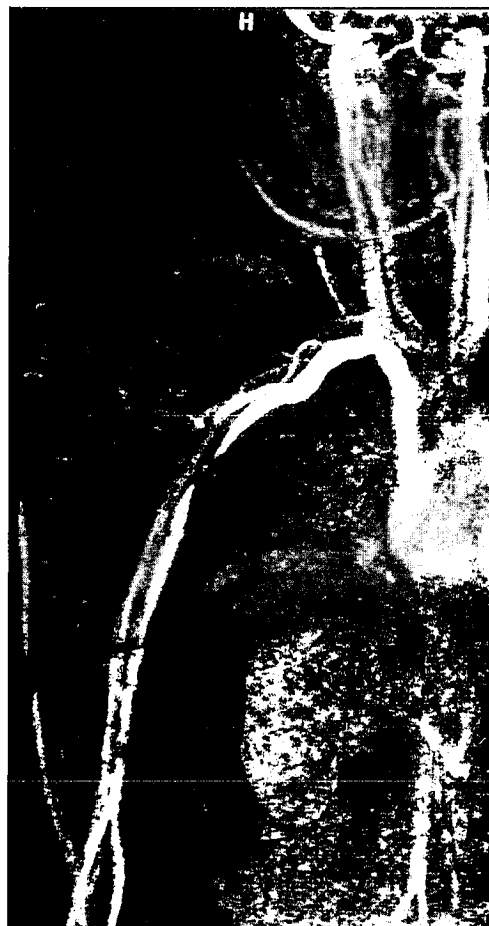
Contrast enhanced MRI angiography shows a stenosis of the subclavian artery and vein.
